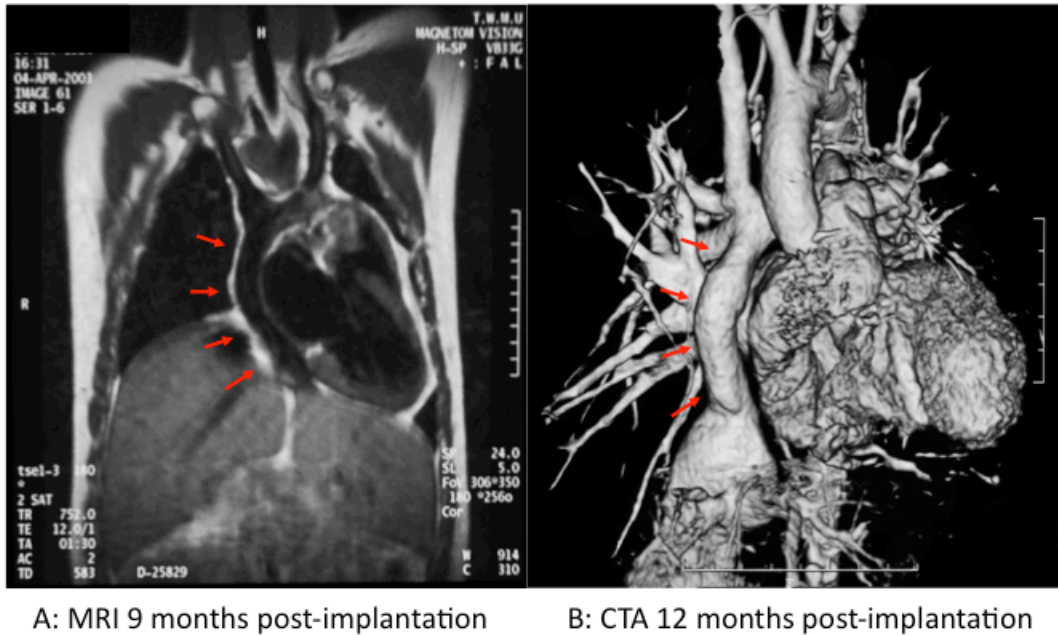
Growth potential of TEVG in clinical trial. A. Magnetic resonance image (MRI) 9 months following implantation of EC TCPC graft. B. 3-D computed tomography angiogram (CTA) of graft one year after implantation. Red arrows indicate location of tissue engineered vascular graft. (Adapted from Shinoka (2008) [26]).
